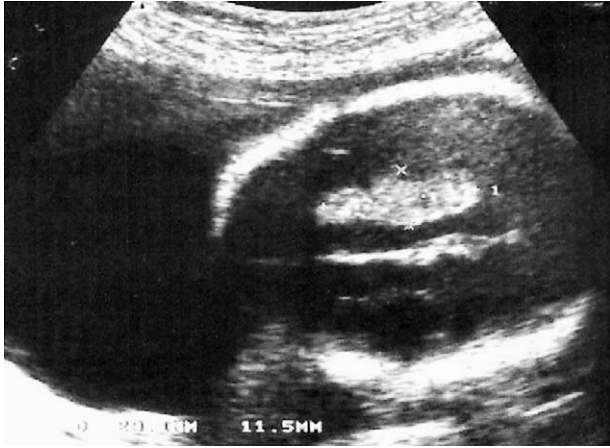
Cranial ultrasonography at the 28th week of gestation (axial section through the mid-portion of the cerebral hemispheres) the left lateral ventricle is larger than the right one, with an irregular echogenic image of 29×11 mm, compatible with a peri-intraventricular hemorrhage.
